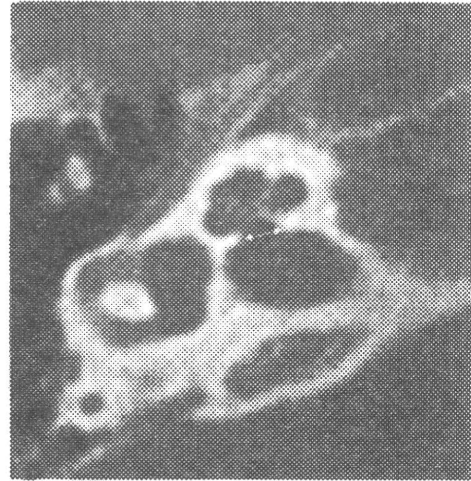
Measurement of CNC on axial image of temporal HRCT. The CNC is the bony canal from the fundus of the IAC to the base of the modiolus. The diameter of the CNC width (line) was measured along the inner margin of its bony walls at its middle portion on an axial image of the base of the modiolus
